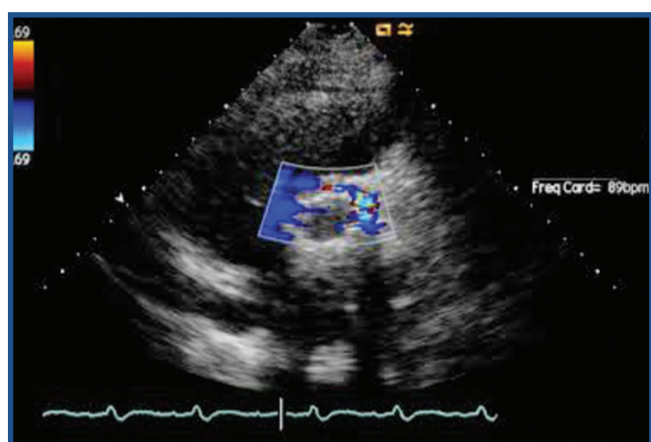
Transthoracic echocardiogram short axis view showing para-prosthetic leak extended from 12 to 4 o'clock.
